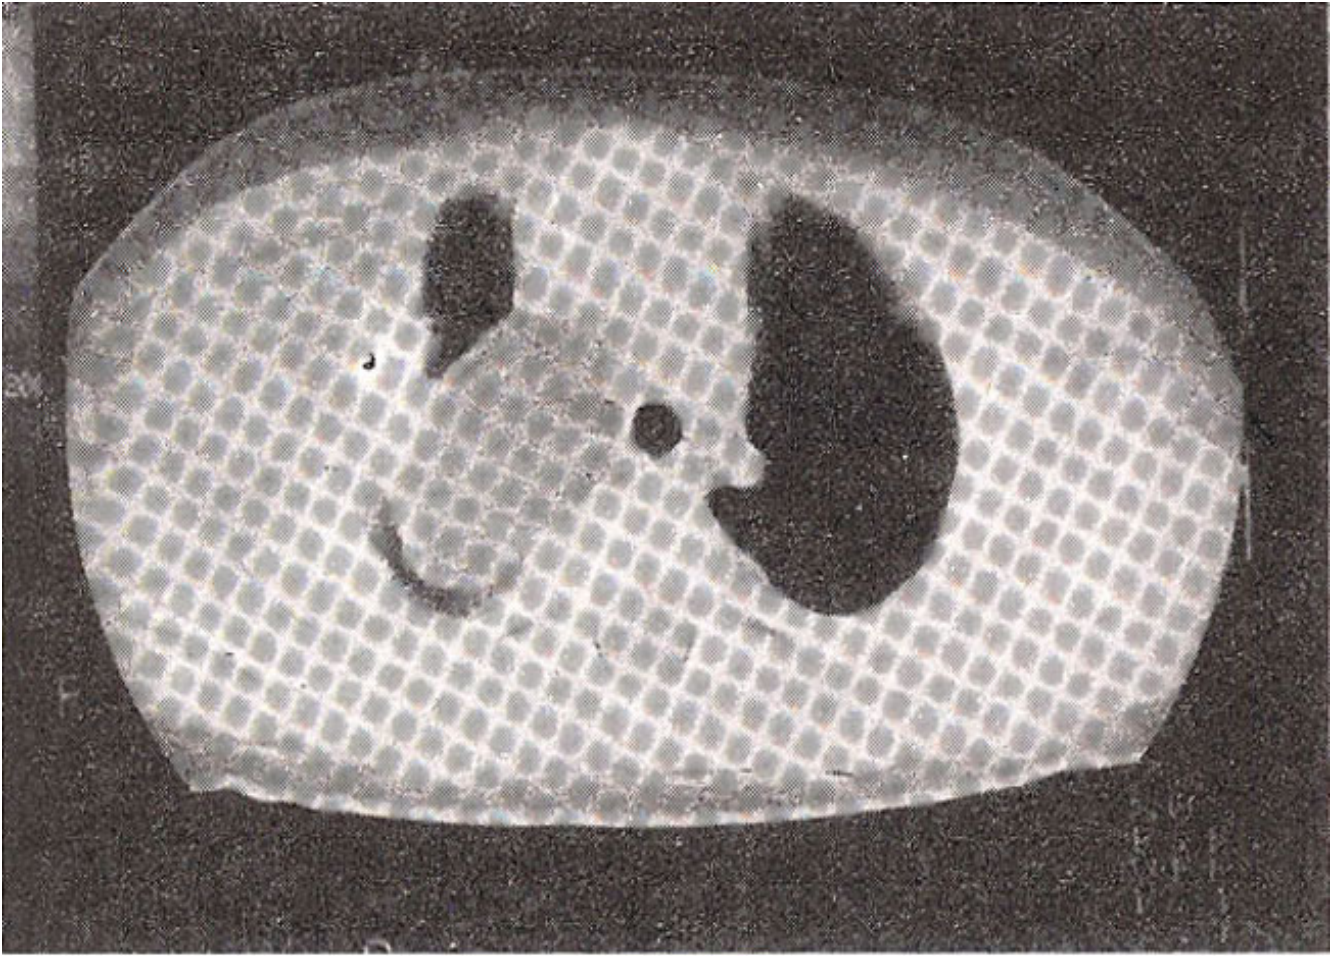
Computed tomography revealing right intrathoracic lipoblastoma with its extrathoracic extension.
